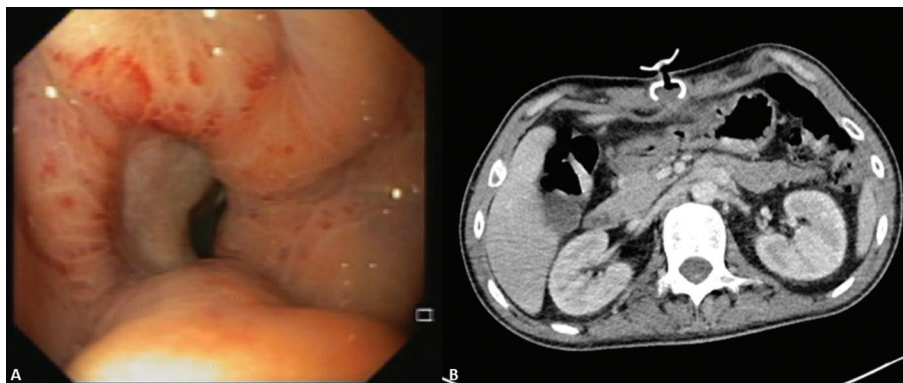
A) Upper digestive endoscopy reveals the internal orifice of the stomal tract after migration of the internal bumper. B) Abdominal CT showing exteriorization of the internal bumper in the fistulous tract.
